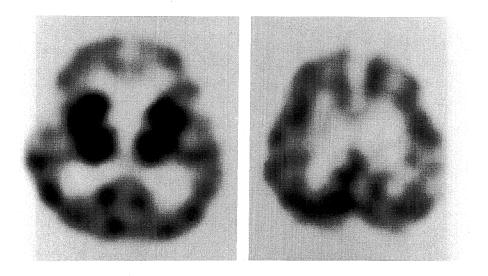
A brain SPECT (99m Tc-HMPAO) shows satisfactory blood flow to the basal ganglia and thalamus, but hypoperfusion of the cerebral cortex
